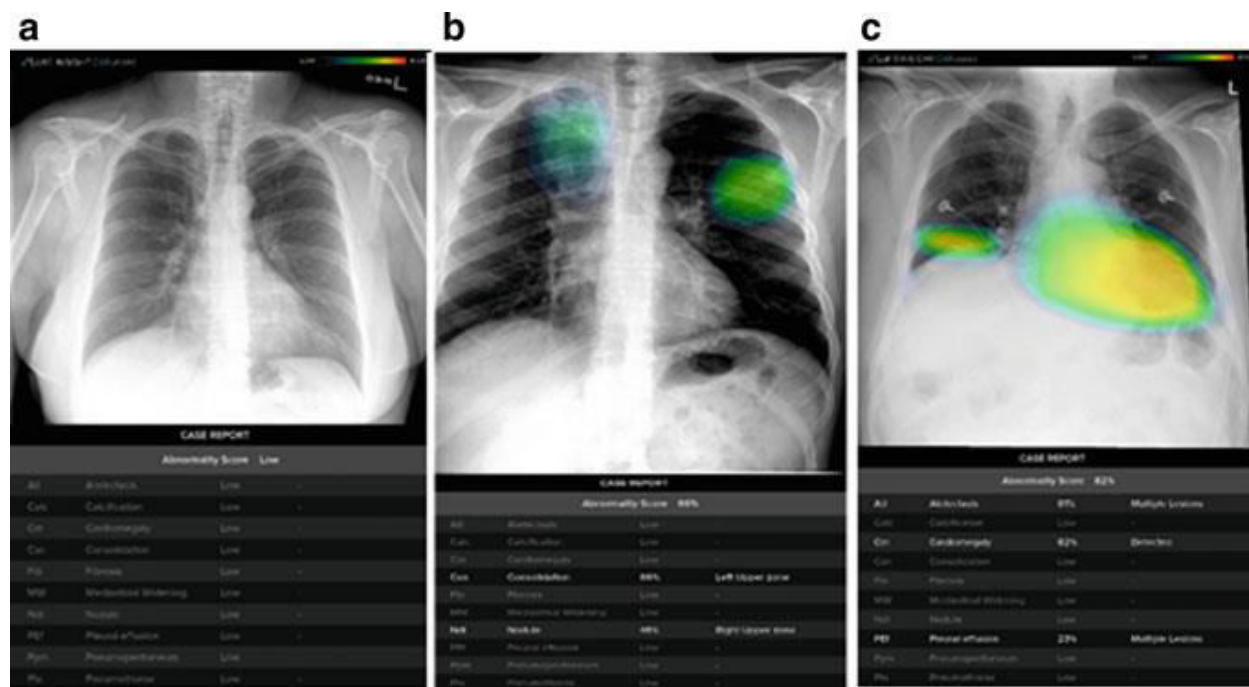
Lunit INSIGHT CXR 3 software output JPG format images for DICOM chest X-ray images.
